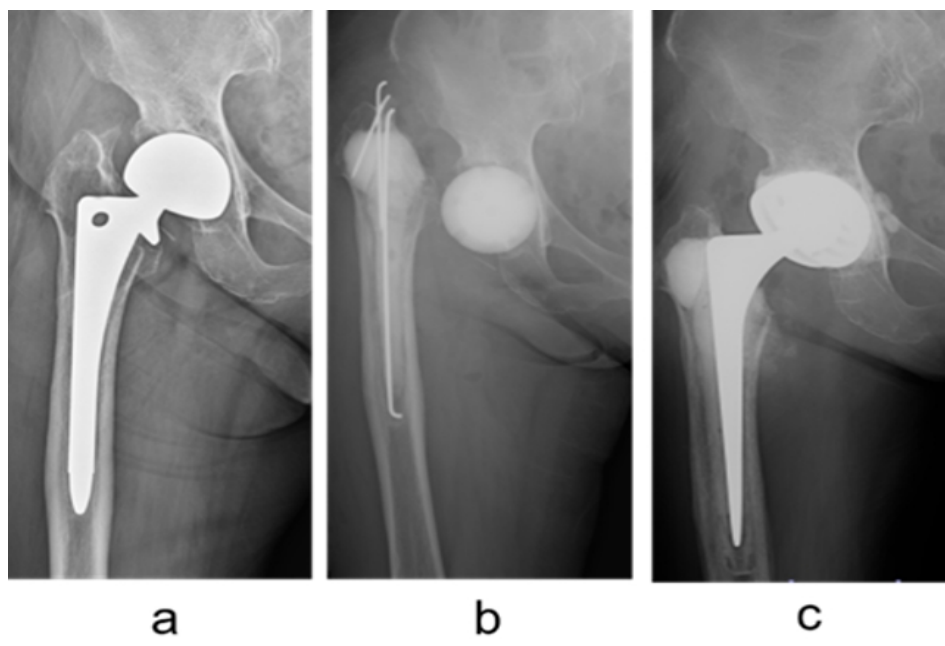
(a) Radiographs obtained at the initial visit. A radiolucent area is observed, and osteolysis is also present around the greater trochanter. (b) Post-operative radiograph showing implantation of the double-layered antibiotic-loaded cement spacer within the hip joint. The bone defect around the greater trochanter was filled with hydroxyapatite paste. (c) Radiograph obtained after revision total hip arthroplasty.
